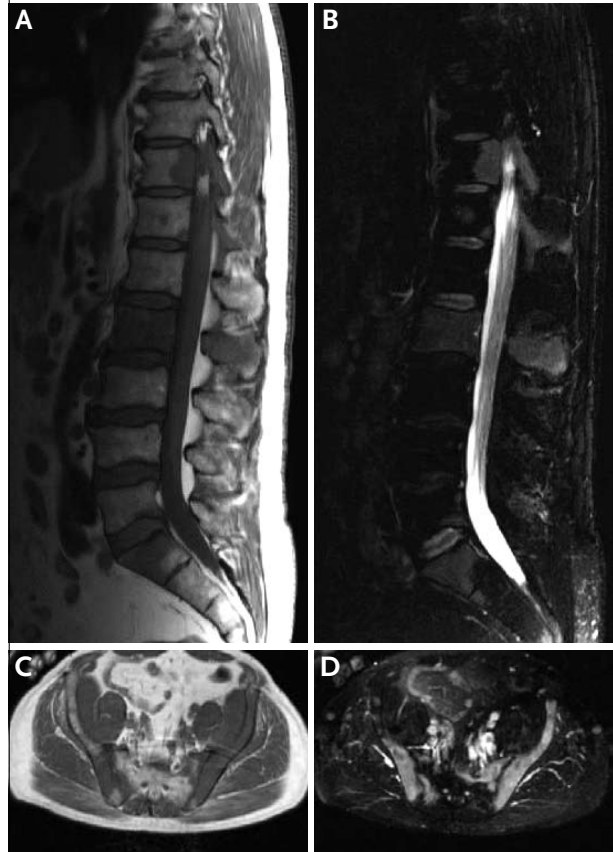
A) Sagittal T1-weighted MRI showing multiple low signal lesions in the vertebral bodies and enlarged abdominal lymph nodes, B) T2-weighted sequences showing hyperintensive vertebral lesions, C) Axial T1-weighted MRI demonstrating hypointense lesions in both iliac bones and D) The iliac lesions have a high signal intensity in T2-weighted sequences
